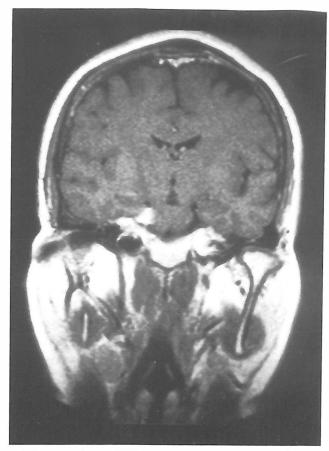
(a-b): Secondary lymphoma: coronal Tl weighted post contrast MR images in two HIV seropositive patients with Hodgkin's lymphoma show perineural extension through the cranial nerve.
